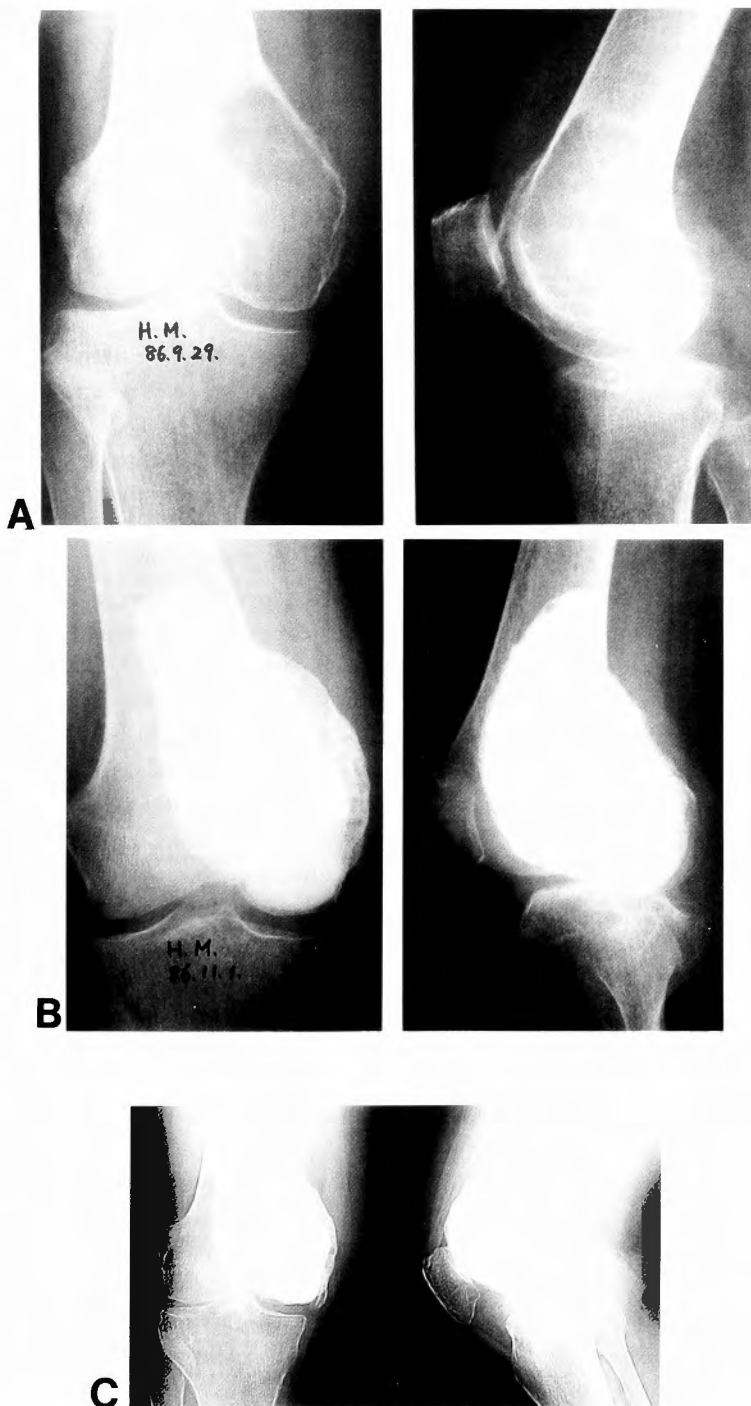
Case 3. 59 year old female. GCT at the distal femur (A). X-ray taken immediately after the operation (B) and 69 months after the operation (C). A degenerative joint change was present, but did not progress after the operation.
